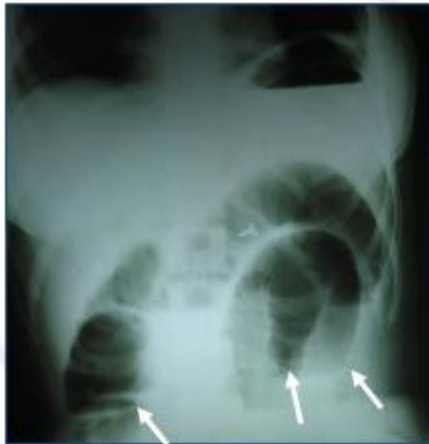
Plain Abdomen x-ray showing multiple fluid levels
